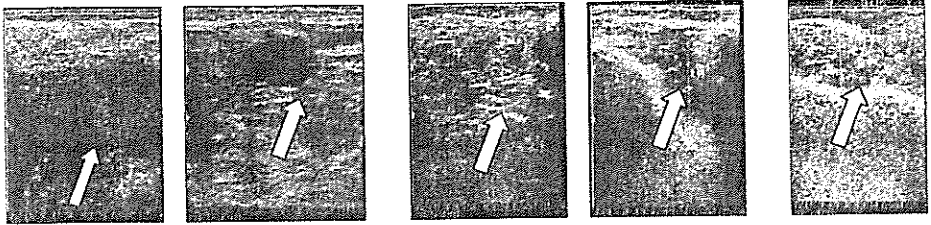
Ultrasonograms of pregnant she-camel at day 34 of gestation.
